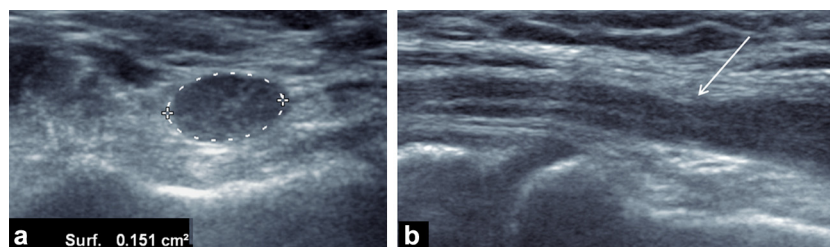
Signs of nerve distress on ultrasound in a patient with ulnar tunnel syndrome confirmed on electromyogram. a: ultrasound image in the transverse plane shows a cross-sectional surface area of 15 mm² and hypoechoogenicity of the nerve. b: longitudinal section: increased diameter of the nerve immediately proximal to its path beneath the presumed position of the ulnar tunnel retinaculum (arrow).
